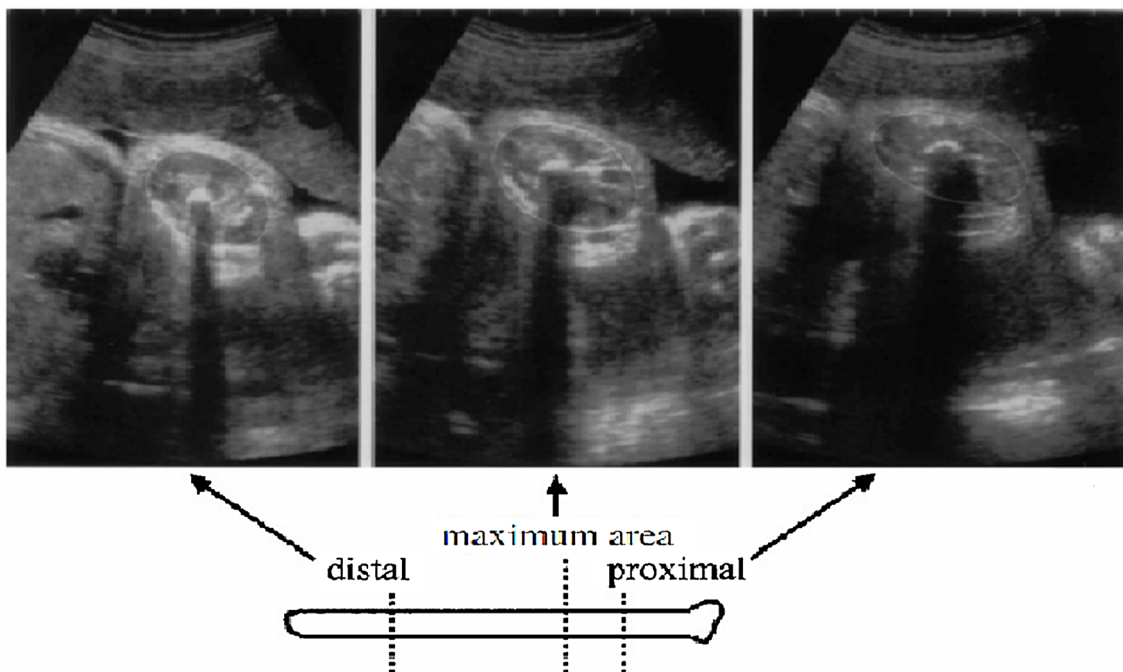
Sonographic views of the cross sectional area of the thigh at right angles to the long axis in the proximal, maximum and distal portions. Isobe [5]
